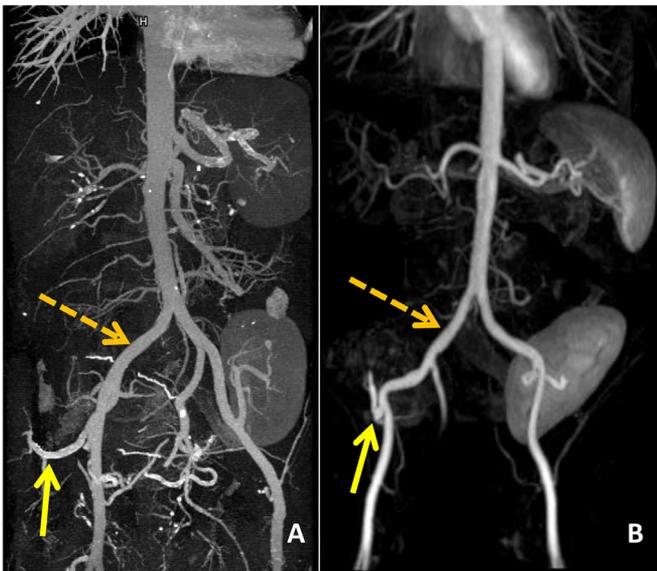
3D reconstructions of the abdominal organs and vasculature after angiography can provide more information about the graft's vascular supply. Image A is an arterial phase reconstruction from a CTA of a 56-year-old male status post Simultaneous Pancreas and Kidney transplants, which demonstrates the transplanted graft artery (solid arrow) arising from the recipient right common iliac artery (dashed arrow). Image B is from the same patient, two years later, demonstrating the same normal vascular anatomy, only this time the patient received an MRA. The renal allograft is identified in the left iliac fossa. (Color version of figure is available online.)
